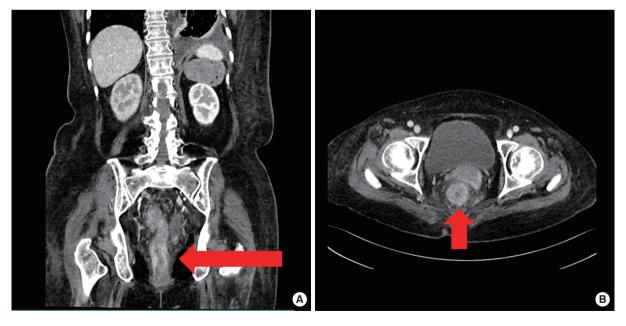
Contrast-enhanced computed tomography scan shows long segmental and concentric rectal wall thickening, suggestive as linitis plastica, with perirectal infiltration (red arrow). (A) Coronal view. (B) Axial view.
